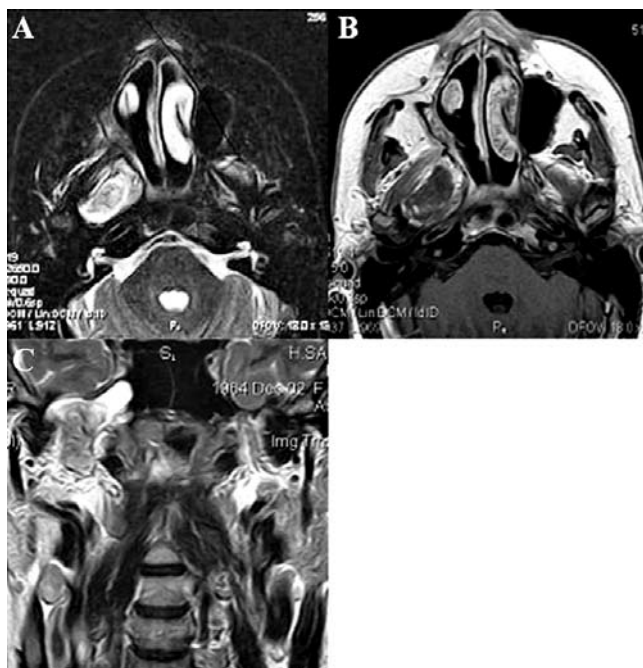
A 40-year-old female affected by a schwannoma occupying entire right parapharyngeal space and involving MS, incorrectly classified as a lesion originating from parotid space by MRI (A. axial STIR sequence; B. axial T1 weighted sequence after gadolinium administration; C. coronal T2 weighted sequence). Lack of identification of surrounding parapharyngeal fat displacement due to massive extension of lesion probably led to erroneous interpretation.
